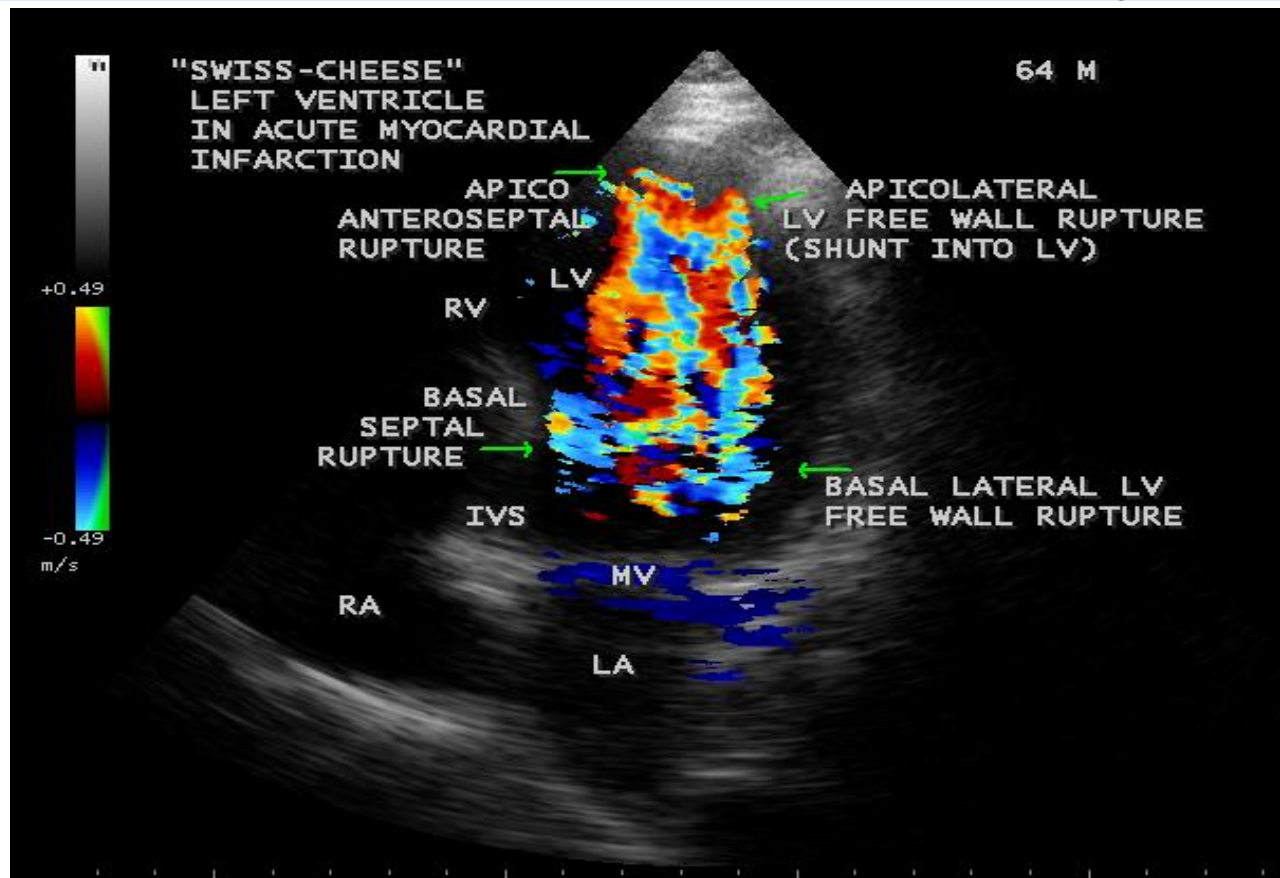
Apical 4 chamber view showing the "Swiss-cheese" left ventricle with multiple sites of ruptures.
